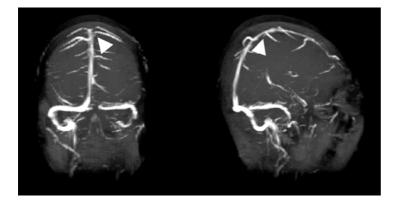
The narrow segment seen resulted from signal attenuation on coronal MRI scan. Because the BBVs overlap partly with venous sinus, such a structural feature disappeared if the view position was rotated for the same patient.
